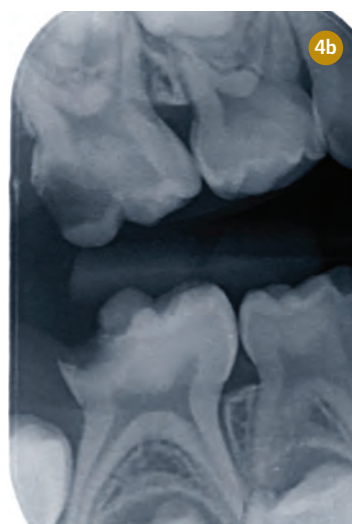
Right vertical bitewing of patient in Figure 4a. Note first primary molars appear caries free.
